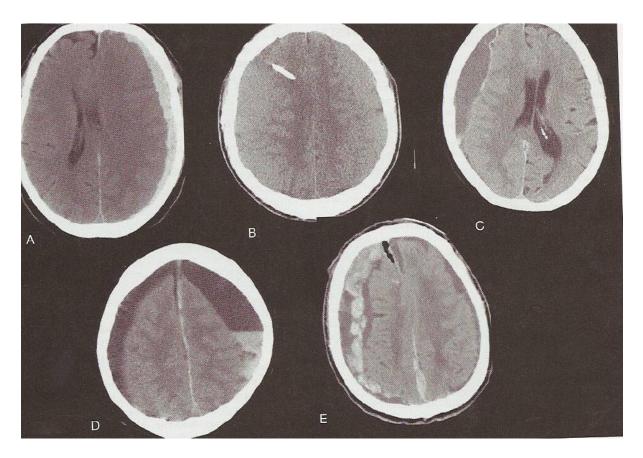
CT scan findings as outlined by Normura et al 26
